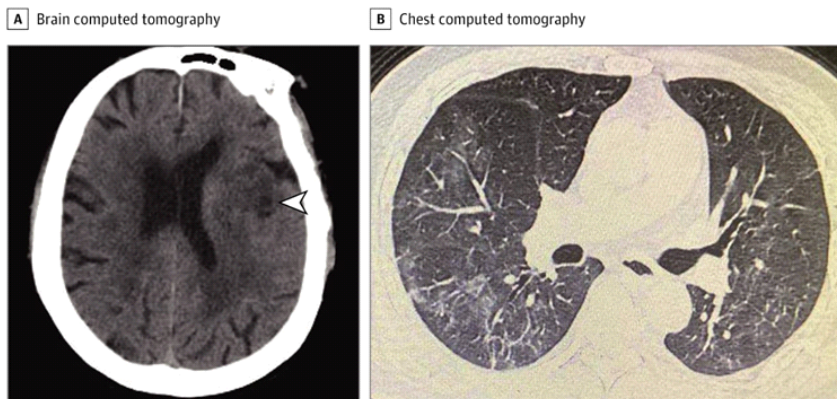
(A) CT Scan brain shows left MCA territory infarct in case 2, (B) CT S Thorax shows bilateral ground glass opacities in case 3
